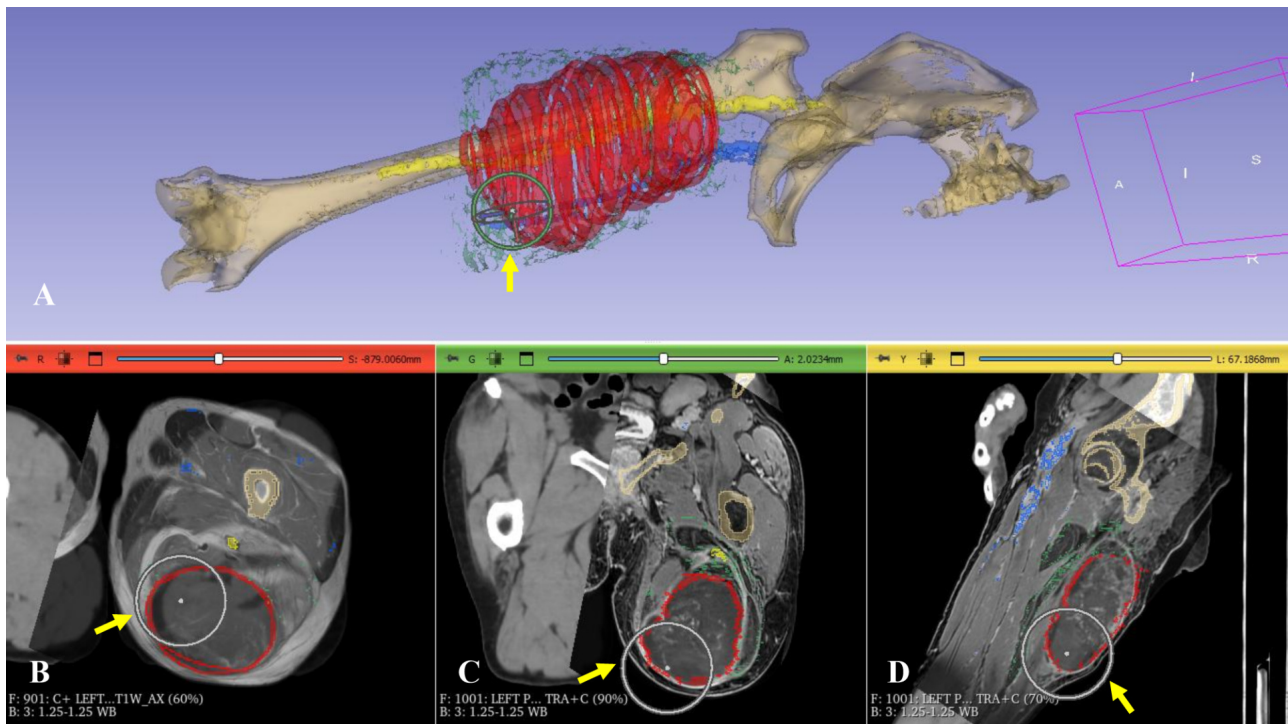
In a patient with high-grade soft tissue sarcoma of the thigh, multimodal image fusion (B–D) was performed, and 3D models (A) were created after mapping the tumor, vessels, and nerve onto the fused images in 3D Slicer. For CT-MRI fusion, the MRI images were matched with the CT images using the positional controller (yellow arrows).
